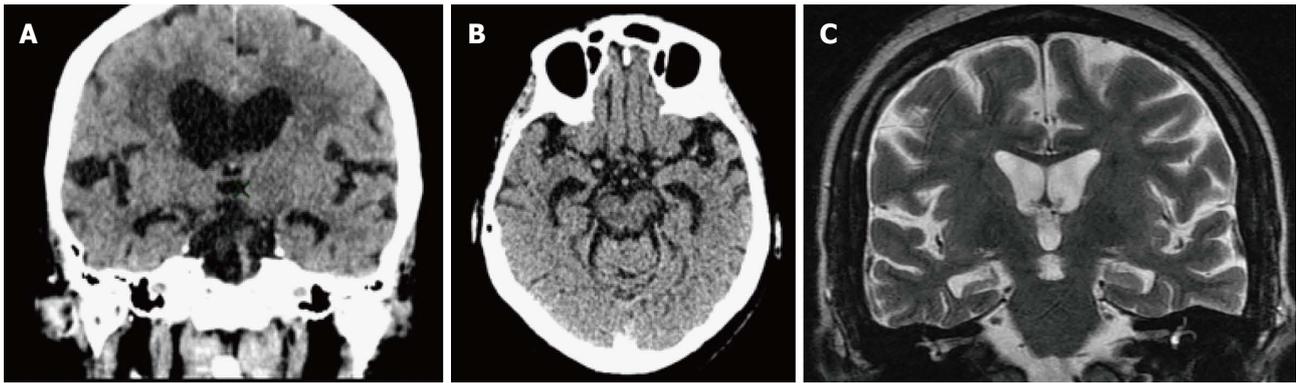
Hippocampal atrophy in an Alzheimer's disease patient. A: Computed tomography axial; B: Coronal images; C: Medial temporal lobe atrophy on magnetic resonance imaging (not the same patient).
